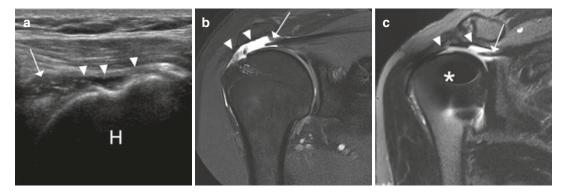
Recurrent tears seen on imaging. (a) Longitudinal B-mode ultrasound and (b) coronal oblique T2-weighted fat suppressed MRI images of the same patient post supraspinatus tendon repair demonstrates a large fluid defect (arrowheads) in keeping with re-tear/Sugaya grade V. The tendon stump is retracted medially (arrows) and appears like a type 1 re-tear. *H* humeral head.
